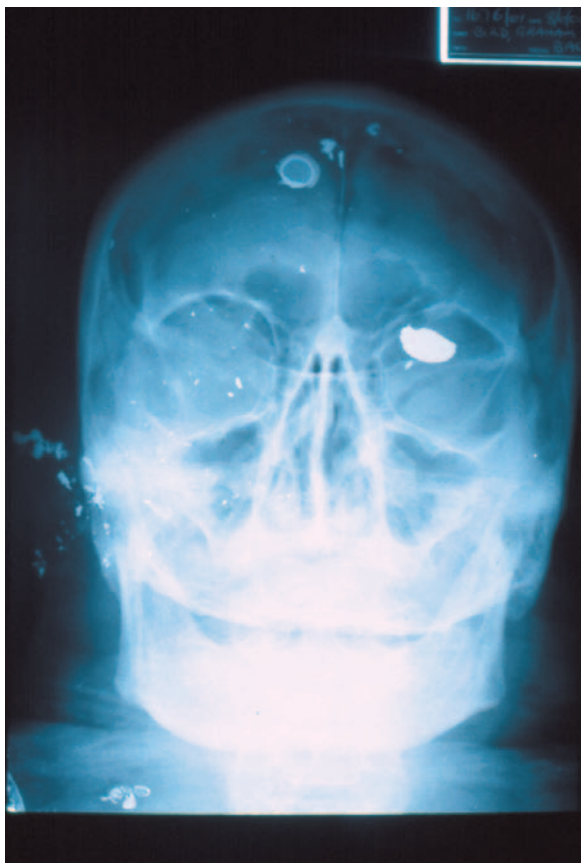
A classic radiograph showing a solitary intracranial .38 Special projectile fired through the right mastoid process. The jacket has completely separated and is seen above the right frontal sinus end on.
